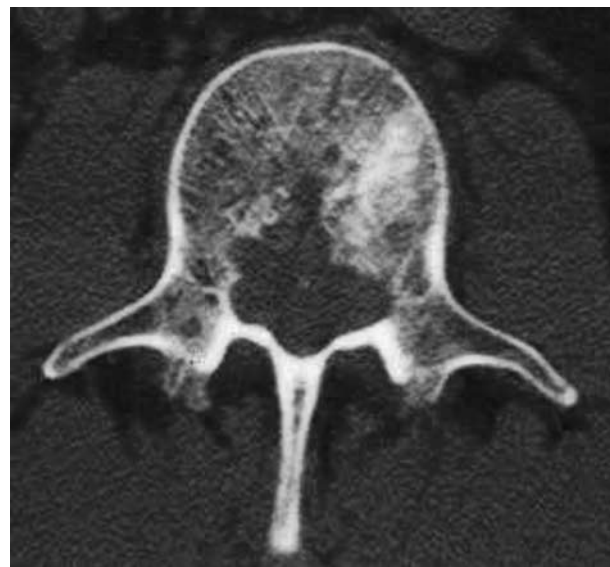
Prebiopsy computed tomography—axial image showing the location of the initial tumor to be biopsied, the biopsy was performed through an open laminectomy, thus violation of the tumor and seeding of tumor cells in epidural space.
